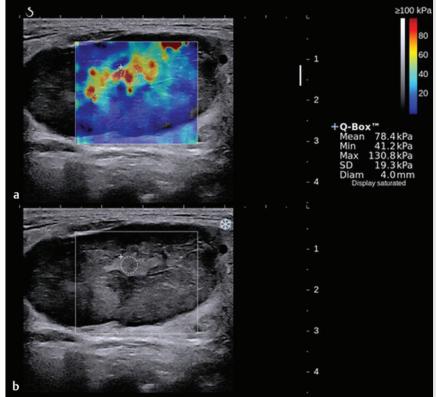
(a) 2D-shear wave elastogram and (b) corresponding B-mode ultrasound image of a metastatic lymph node. The B-mode image shows the loss of fatty hilum and cortical heterogeneity while the elastogram reveals heterogeneous, high stiffness (red) areas. The maximum shear modulus (max SM) value of 130.8 kPa suggests a metastatic region.
